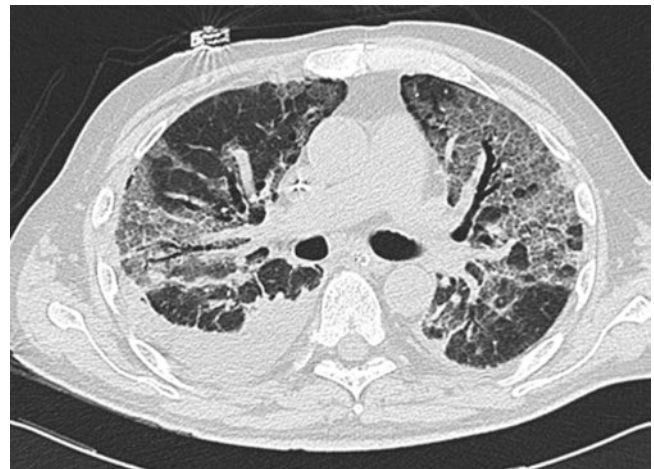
Typical appearance of ARDS on CT: diffuse heterogeneous ground-glass opacities with thickened interlobular septa, more dense consolidation in dependent areas (Courtesy of *European Respiratory Review Dec 2014;23(134):519–30*; <https://doi.org/10.1183/09059180.00001314>)
